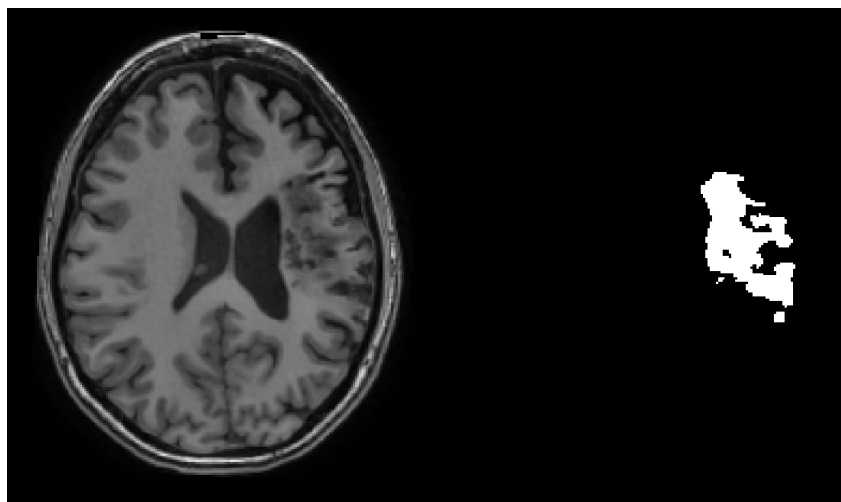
MRI Image and Mask.
